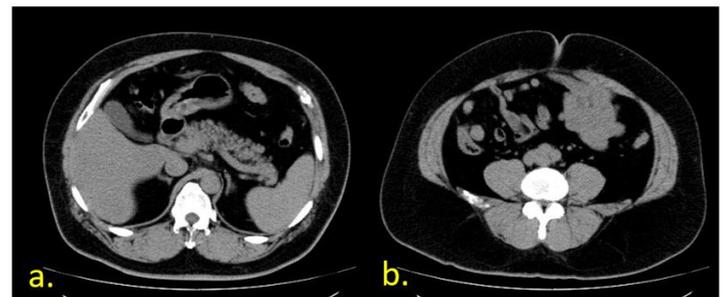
Abdominal CT scan in Apr 2023
